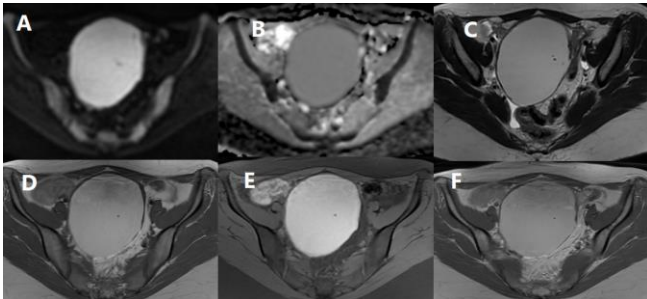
(A) DWI, (B) ADC map, (C) Axial T2, (D) Axial T1 pre-contrast, (E) Axial T1 fat sat, (F) Axial T1 post-contrast show left ovarian large unilocular hemorrhagic cystic lesion (Endometrioma) is seen with fine internal incomplete septations. No solid component. It displays DWI high signal (A), low ADC map signal (B) high T2 signal (C), high signal in T1 (D), high signal in T1 fat sat WIs (E) with no pathological post contrast enhancement (F). The ADC value is around $0.8 \times 10^{-3} \text{ mm}^2/\text{s}$.
